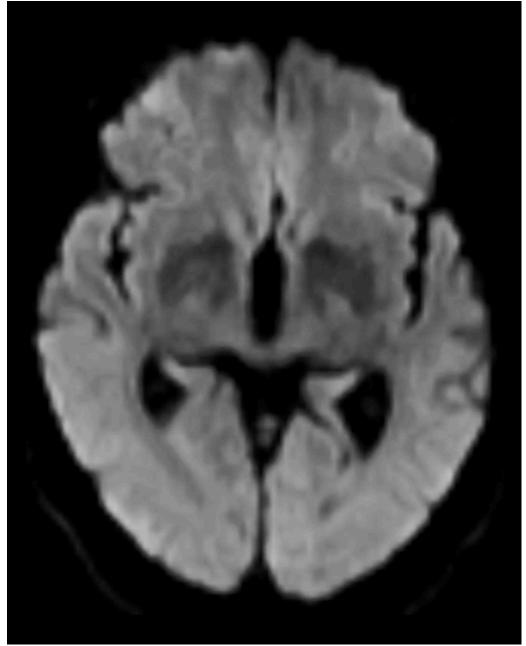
Brain MRI shows no signs of diffusion restriction
